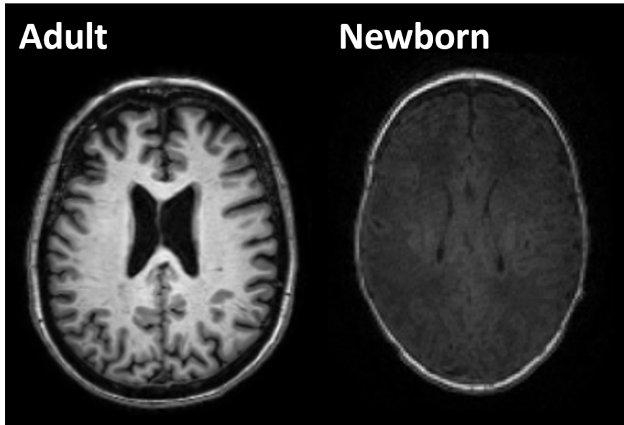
T1-weighted MR images of an adult subject (left) and newborn subject (right). Notice that the WM and GM tissue contrast is inverted and has poorer contrast on the newborn scans. The newborn image also has noticeable motion artifacts.
